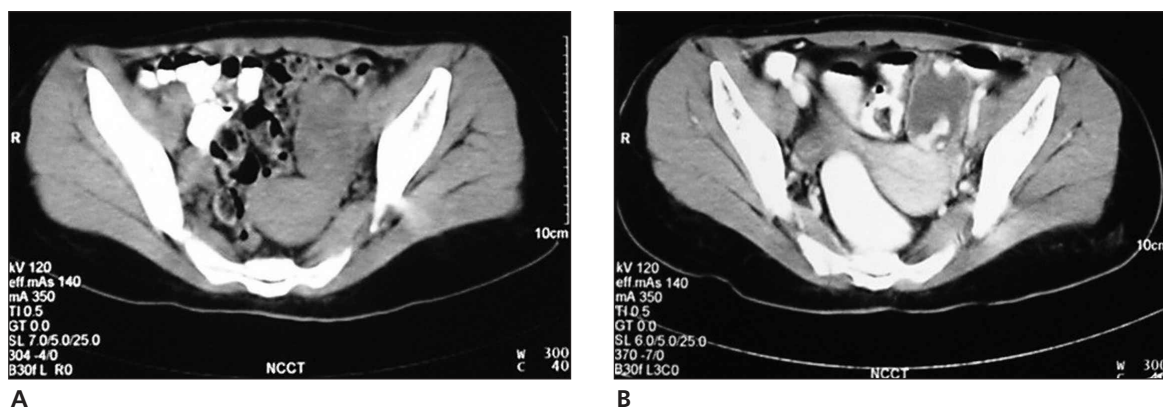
A, Non-contrast-enhanced CT showing a well-defined hypodense left adnexal mass. B, Axial contrast-enhanced CT showing a well-defined hypodense mass limited to the left adnexa with areas of nodular enhancement.
